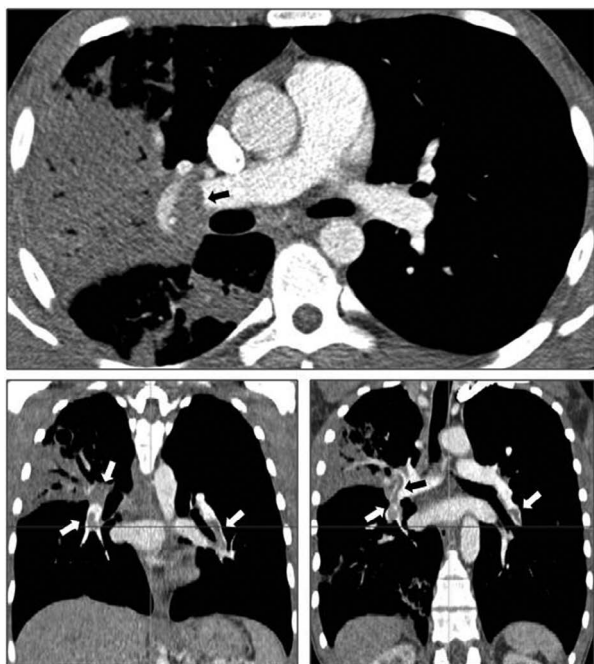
Computed tomography (pulmonary angiography) with multiplanar reconstruction. Bilateral emboli mainly in the right pulmonary artery and its branches (arrows). Large consolidation in the right upper lobe
